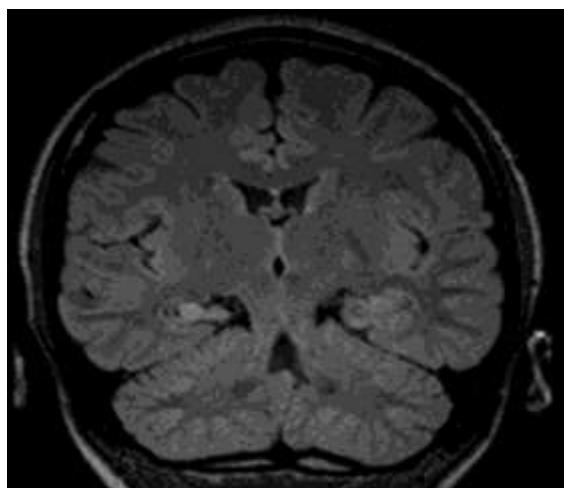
Comparison of normal and sclerotic hippocampus on coronal FLAIR images demonstrating
